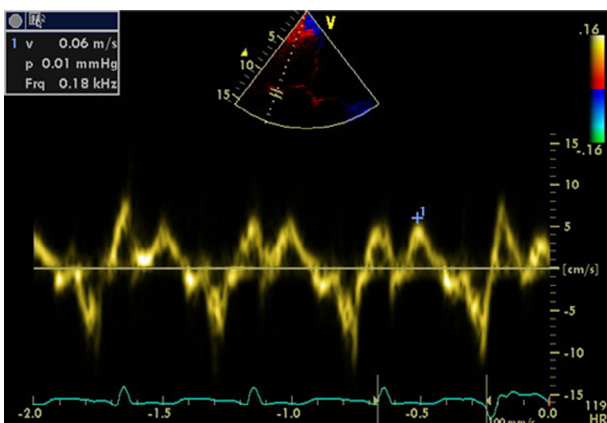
Tricuspid annular tissue Doppler imaging. Peak myocardial systolic velocity S' wave which was diminished in this patient (6cm/s).
